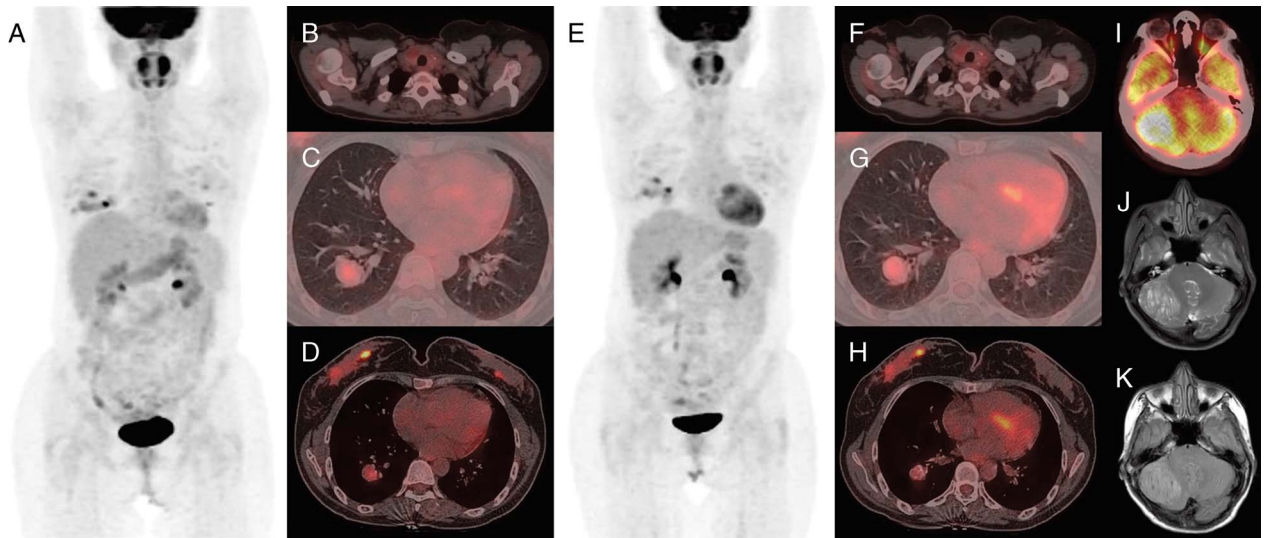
A 39-year-old woman with a medical history of colon polypectomy was referred to ^{18}F -FDG PET/CT scan for evaluating cancer of unknown primary due to multiple pulmonary nodules discovered on the thorax CT, which were evaluated in favor of metastases. MIP (A) and axial PET/CT images revealed mild-to-moderate hypermetabolic multinodular thyroid goiter (B) and multiple nodular lesions on both breasts (D). Increased FDG uptake was observed in multiple pulmonary nodules with calcification in both lung parenchyma, suggesting lung cancer (C). Also, intense FDG uptake (SUV_{max} , 13; tumor-to-contralateral cerebellum uptake ratio, 1.4) was depicted in the 5-cm measured hypodense mass lesion in the right cerebellar hemisphere suspicious for metastasis (I). The mass lesion showed tiger-stripped pattern of hyperintensity on T2-weighted MR images without contrast enhancement (J and K), suggesting the diagnosis of Lhermitte-Duclos disease (LDD). The hamartomatous nature of the lesions along with LDD in the cerebellum lead to the diagnosis of Cowden syndrome (CS) and a year after, the tumors remained stable without a specific treatment (E, MIP; F–H, axial fused PET/CT images). LDD is a rare disorder characterized by a slowly growing hamartomatous tumor within the cerebellar cortex. Characteristic MRI findings including tiger-stripped pattern on T2-weighted images and increased perfusion without contrast enhancement are pathognomonic for the diagnosis. Mild-to-moderate FDG uptake has been previously reported in LDD.^{1,2} High FDG uptake in LDD may lead to misdiagnosis and unnecessary surgical procedures.³ The mechanism of high FDG uptake in this benign tumor remains unknown but is sought to be related to the increased density of dysplastic cells.⁴ Recent studies have revealed a close relationship between LDD and CS, also called multiple hamartoma-neoplasia syndrome, and adult-onset LDD is reported to be identical to CS.⁵ CS is characterized by multiple benign tumors including mucocutaneous lesions, systemic hamartomas, gastrointestinal polyps, breast fibroadenomas, multinodular goiters, and increased risk of other neoplasms such as breast, thyroid, and endometrial cancers.⁶ Whole-body FDG PET/CT has an emerging role in determining the presence/absence of cancer in CS.^{7,8} Our case indicates that intense FDG uptake in such benign tumors including LDD can be misinterpreted as malignant disease; CS should be considered for correct interpretation of the PET activity to save patients from unnecessary surgery or chemotherapy.
